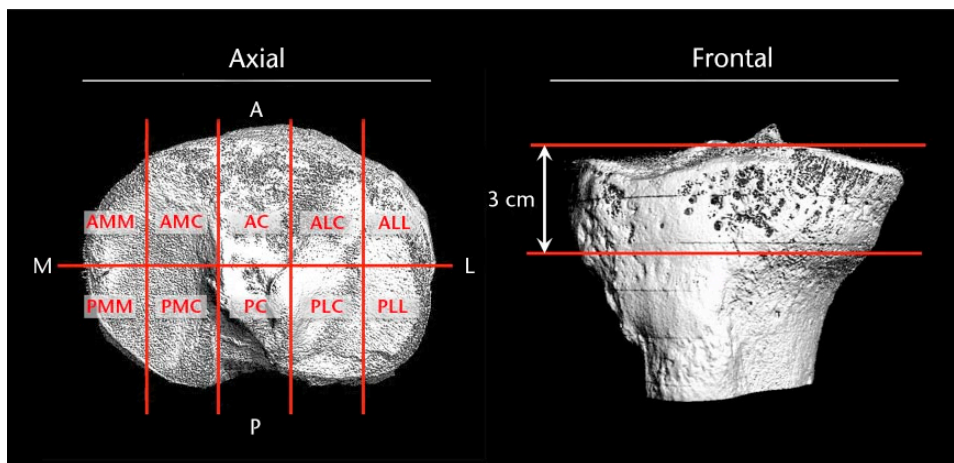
Classifying tibial plateau fractures by ten segments in a CT model may help to choose an appropriate approach. Reprinted from Krause M, Preiss A, Müller G, et al. Intra-articular tibial plateau fracture characteristics according to the “Ten segment classification”. *Injury* 2016;47:2551-2557, with permission from Elsevier.
